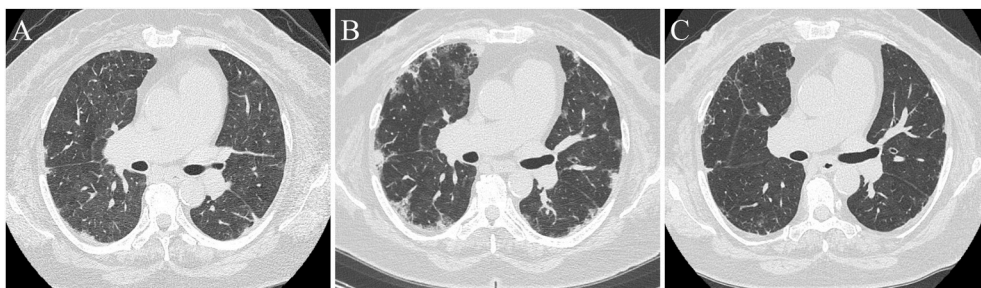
Chest CT findings at the time of admission (A), after the administration of a corticosteroid and tacrolimus (B), and after six cycles of chemotherapy (C). Conventional CT of the chest revealing mosaic attenuation, with patchy GGOs and a slight subpleural consolidation at the time of admission (A). Even after initiating steroid and tacrolimus therapy, GGOs and consolidation worsen (B). Mosaic attenuation, GGOs, and consolidation in both lungs are improved after chemotherapy (C). CT: computed tomography, GGO: ground-glass opacity.
